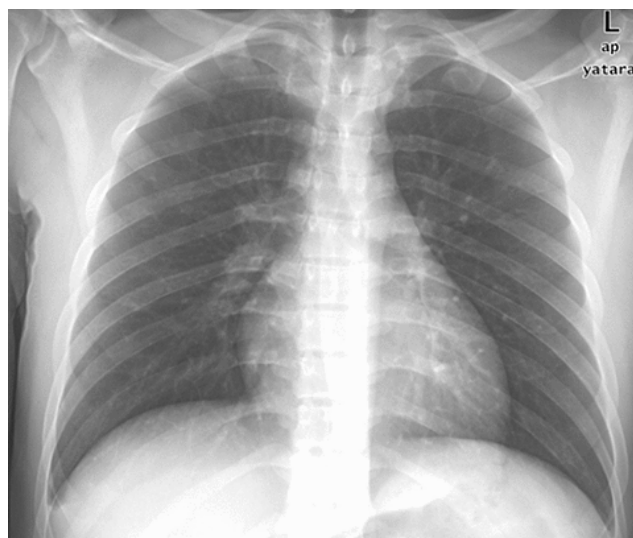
b: Control chest radiograph after treatment
